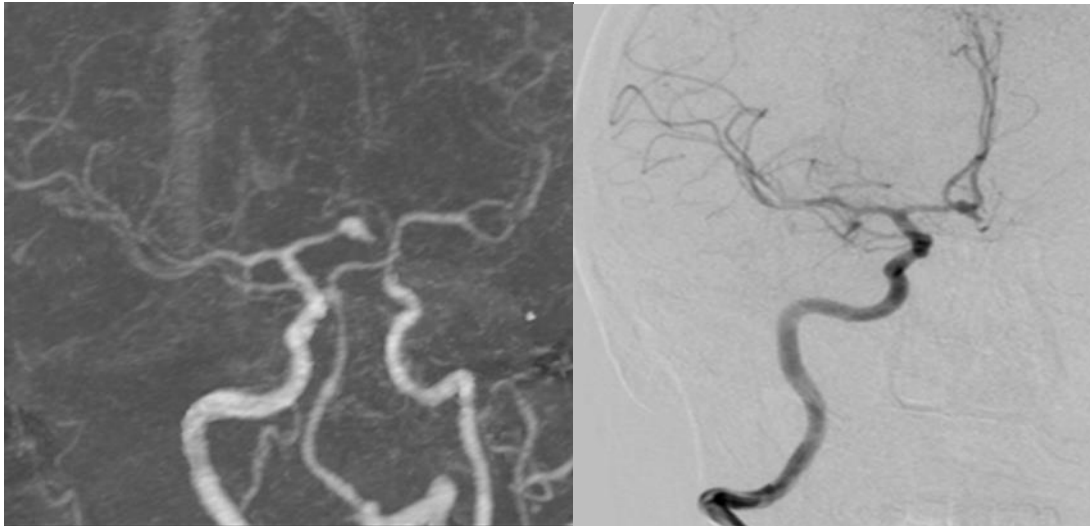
Initial CTA of bilateral A2 and DSA of left A2 before EVT, 61-year old patient with ruptured aneurism of anterior communicant artery, bilateral angiospasm, treated with IV Nimodipine on admission, there is relaxation of VS
